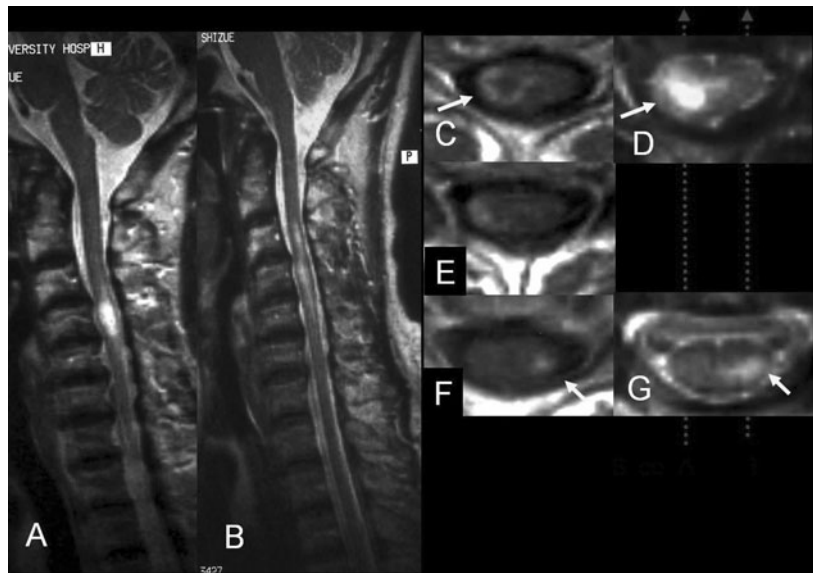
Spinal cord MRI of patient 9. Sagittal T2WI revealed high intensity lesions at the C3 (A) and C3–5 (B) levels. Axial T2WI (D, G) showed high intensity lesions in the lateral to posterior posterior columns on both sides. Focal Gd-enhancing lesions (*arrow*) were localized in the lateral columns bilaterally (C, E, and F).
